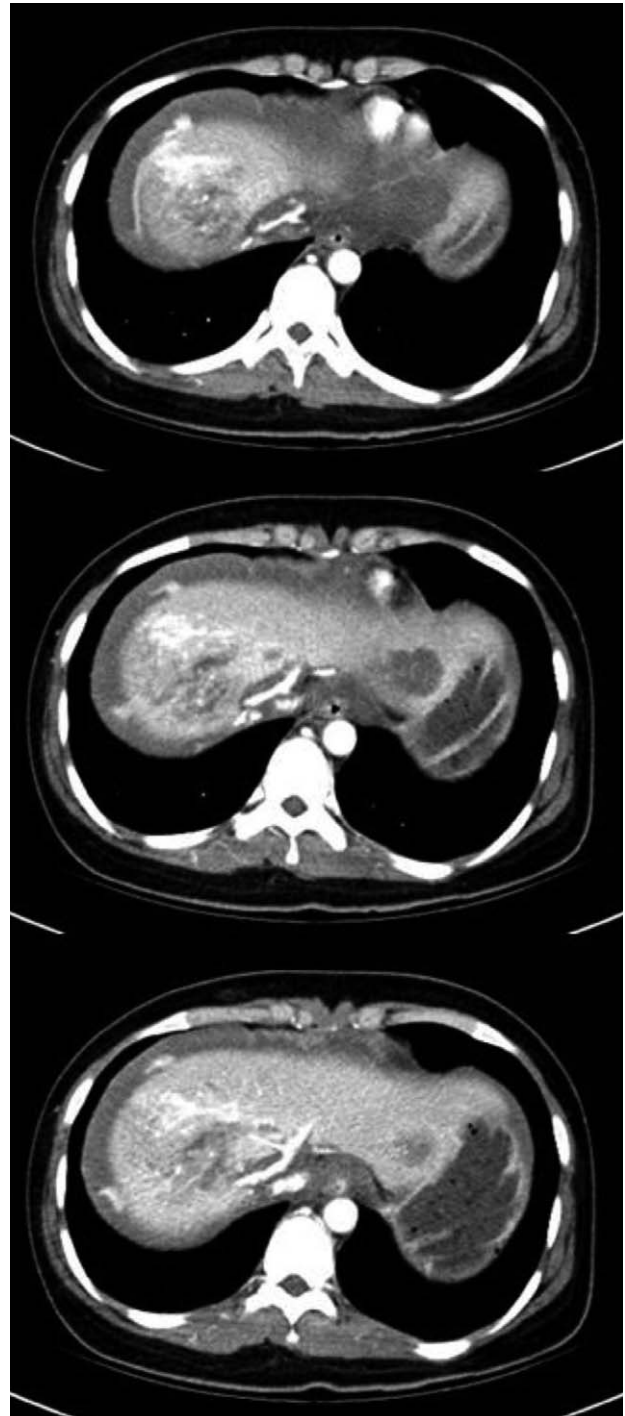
Three consecutive cuts of Axial CT scan at the level of juxtahepatic IVC demonstrate blunt hepatic injury and thrombus inside the IVC.
